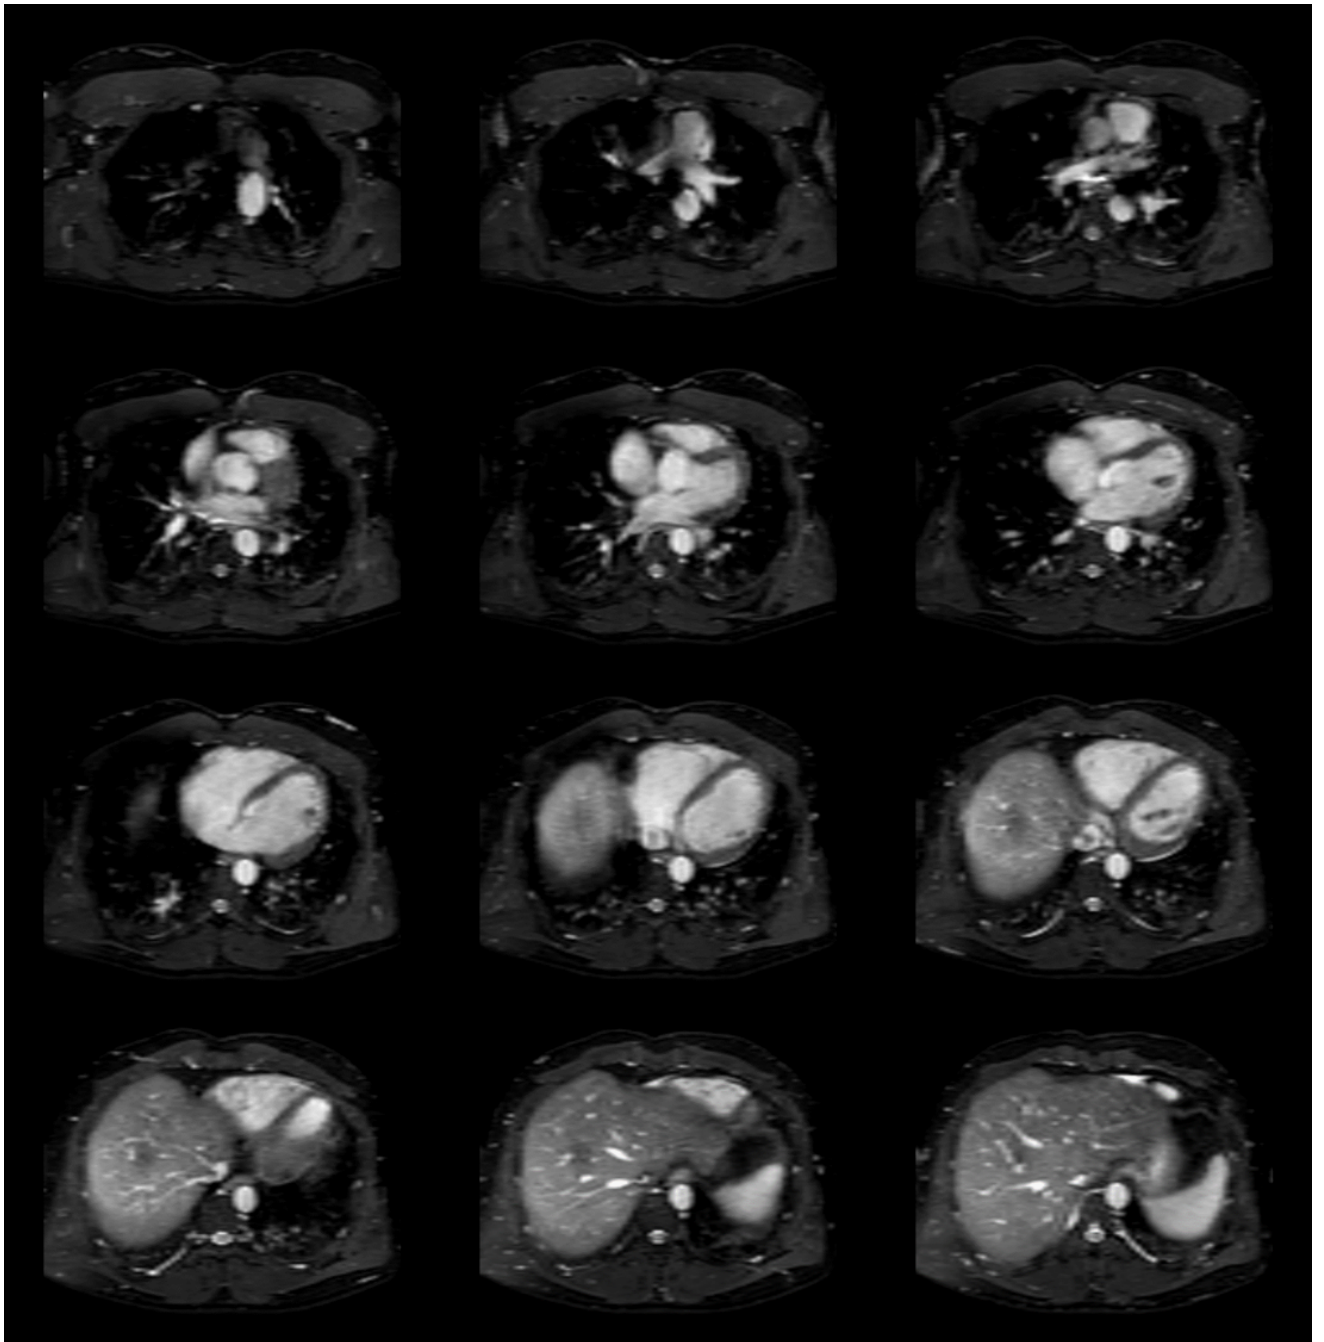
The axial view for the MRI of the third volunteer. Each picture represents one axial layer of the MRI, the distance between the axial layers is 10.5 mm and the original resolution distance is 1.5 mm
